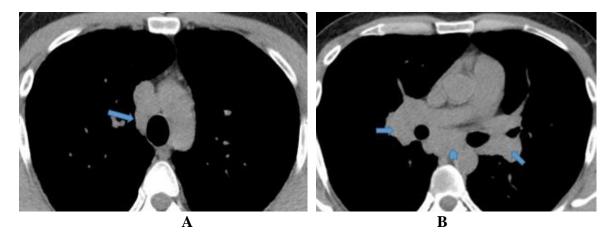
2A. High Resolution Computed Tomography in soft tissue window showing right paratracheal adenopathy. 2B. Shows bilateral and symmetrical hilar adenopathies (straight arrows) and conglomerate of subcarinal adenopathies (arrowhead).
